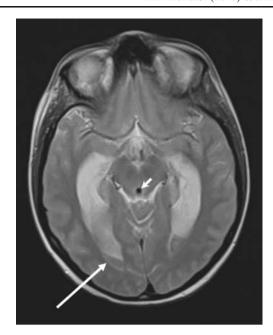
T2-weighted magnetic resonance imaging (MRI), axial plane of the temporal lobes of the brain, done 4 weeks after computed tomography (Fig. 1). MRI shows a widened ventricle system with wide temporal horn and sedimentation of blood in the posterior horn (*long arrow*) and low signal in the cerebral aqueduct (*short arrow*). The outer cerebrospinal fluid spaces are narrowed
